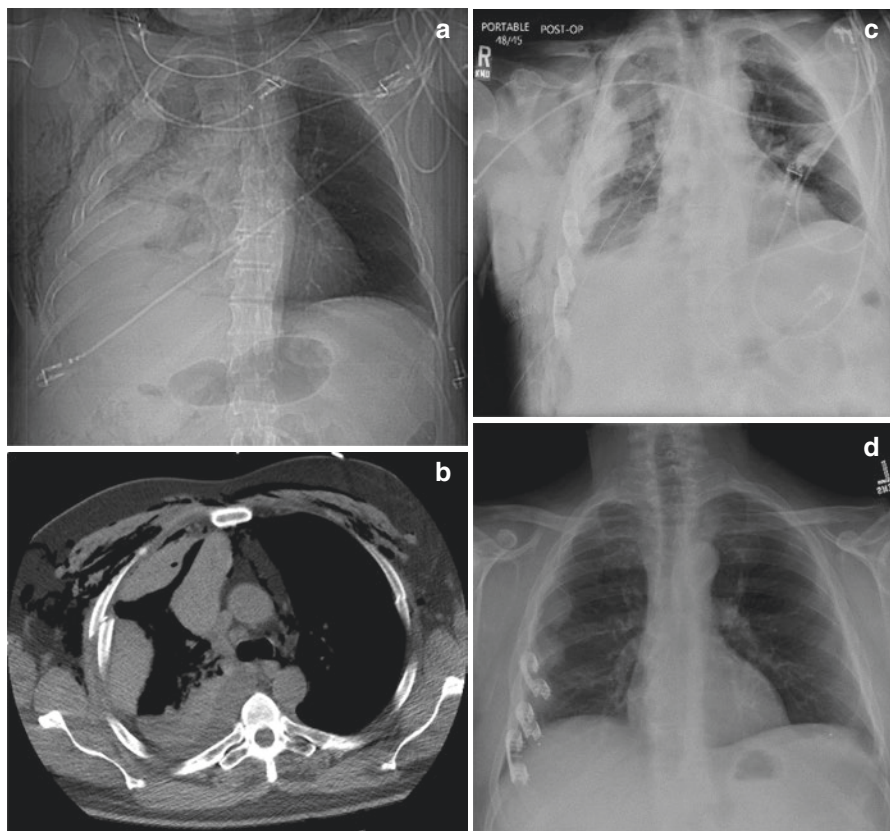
Thoracic CT. A 57-year-old man was involved in fall down 12 stairs landing on his right side. Initial CXR and CT imaging revealed bilateral rib fractures with multiple sequential ribs (2–7) on the right fractured in two locations consistent with flail chest morphology, large volume right hemothorax and pulmonary contusion of most of the right lung and small pneumothorax, pneumomediastinum, and subcutaneous emphysema. Right tube thoracostomy drained 400 cc of blood and minimal thereafter. Thoracic epidural was placed for pain control. He was admitted to the ICU for monitoring and did not require intubation. He had worsening pain and worsening respiratory insufficiency related to unstable right flail chest. (a, b) This patient underwent VATS/rib fracture fixation which resulted in marked improvement in chest wall pain and prompt weaning of supplemental oxygen and improved pulmonary toilet. CXR post-op and 1 month later are below. (c, d) The current EAST practice management guideline for pulmonary contusion—flail chest states that surgical fixation may be considered in severe unilateral flail chest or in patients requiring mechanical ventilation when thoracotomy is otherwise required [15]. No large randomized trial data for early rib fracture fixation exist at present, but three small randomized trials and multiple meta-analyses suggest some benefits (decreased pneumonia, ventilator days, and length of stay)
